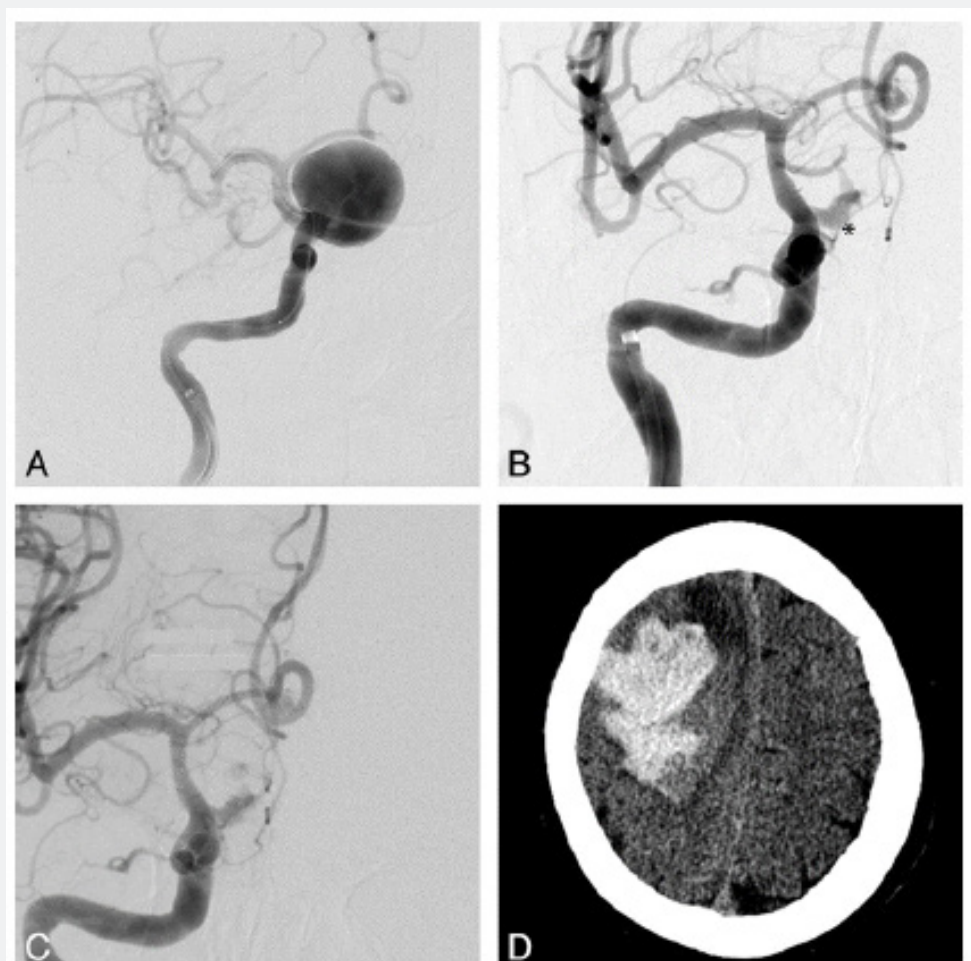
Hematoma following flow diversion in right ICA, adapted from Cruz et al [63]. A, right supragenoid ICA aneurysm before flow diversion. B, right ICA AP angiogram 3 months later, with persistent early aneurysm filling (indicated by asterisk). C, angiogram after deployment of 2 more flow diversions to reduce aneurysm filling. D, axial CT scan showing a large intracerebral hematoma.
